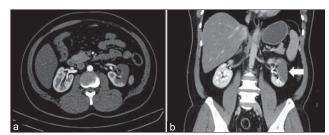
Axial view (a) and coronal view (b) on computed tomography showed decreased attenuation over the upper and middle part of the left kidney (white arrow)
